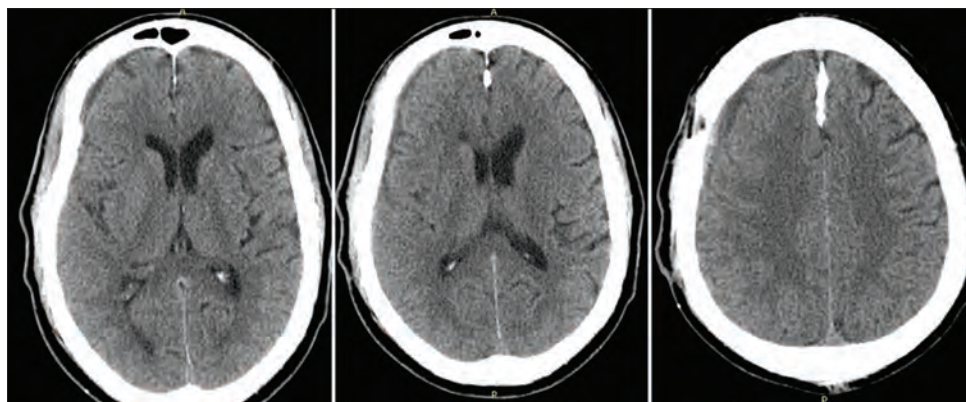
Postoperative computed tomography images showing resolution right chronic subdural collection
